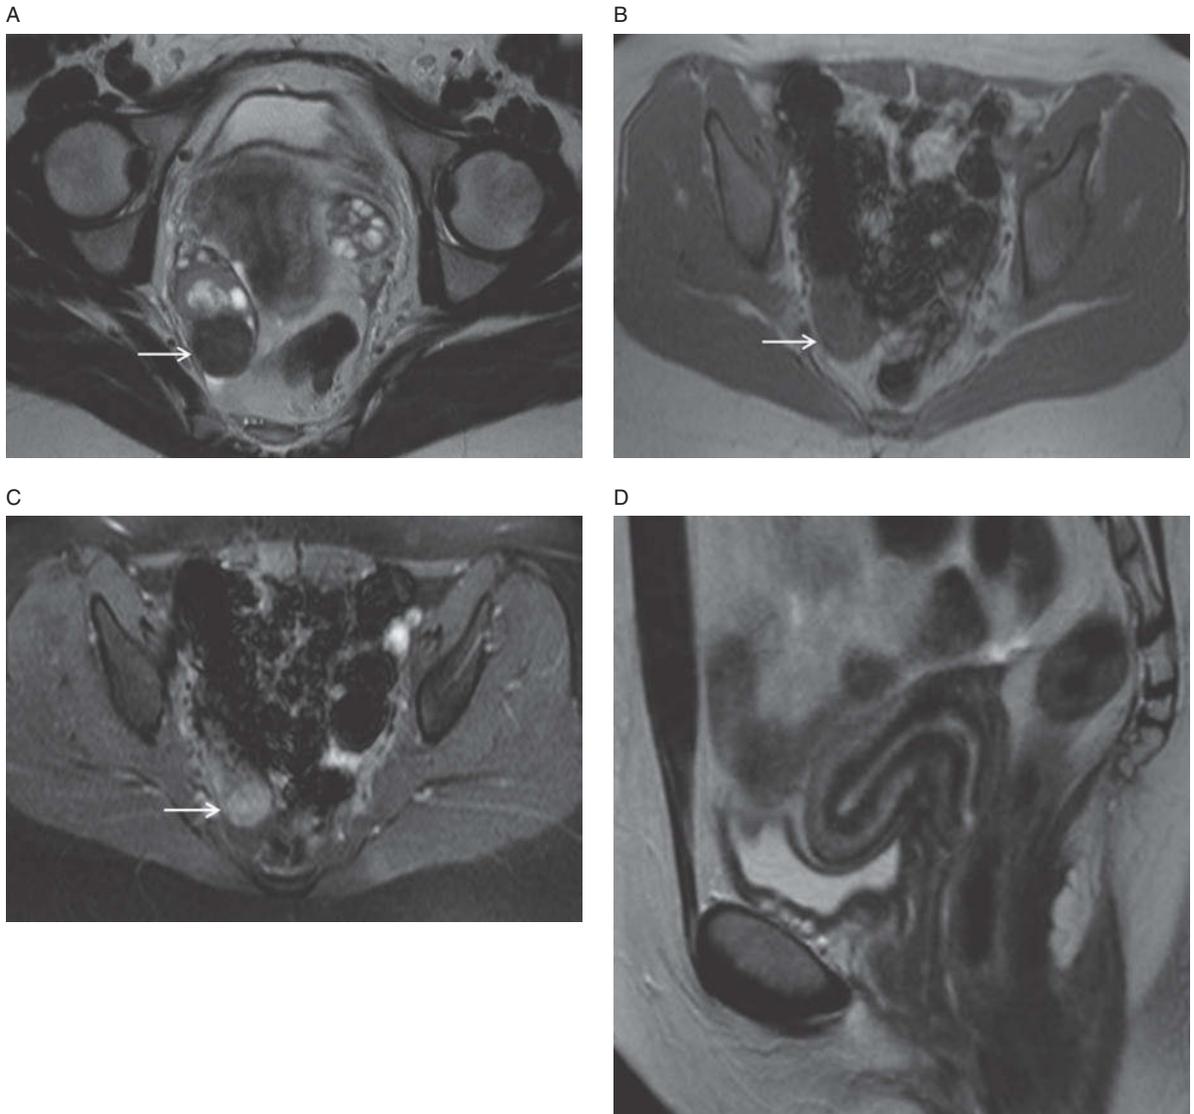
Fibroma in a 65-year-old female. Axial T2-weighted image (A) demonstrates a low T2 signal intensity mass in the right ovary (arrow). The mass is uniformly intermediate in signal intensity (arrow) on the corresponding axial T1-weighted image (B). The post-contrast axial T1-weighted image with fat saturation (C) shows uniform low level enhancement of the mass (arrow). The sagittal T2-weighted image through the uterus (D) demonstrates the absence of endometrial thickening. A normal thickness endometrium in this post-menopausal patient favors that the mass is a fibroma rather than a hormonally active fibrothecoma.
